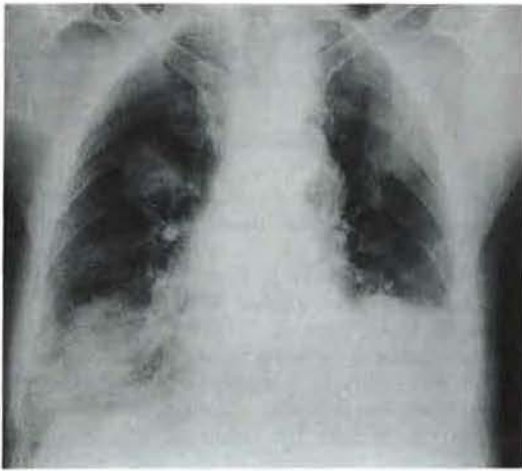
Standard chest X-ray film, April 1987, demonstrating increase in number and size of the multiple bilateral pulmonary opacities.
